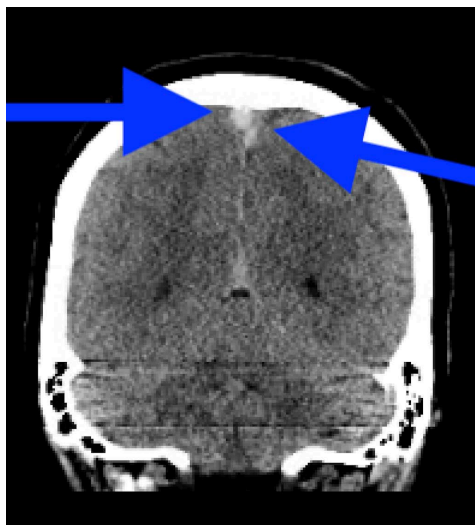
CT Head without contrast showing sagittal sinus thrombosis.
